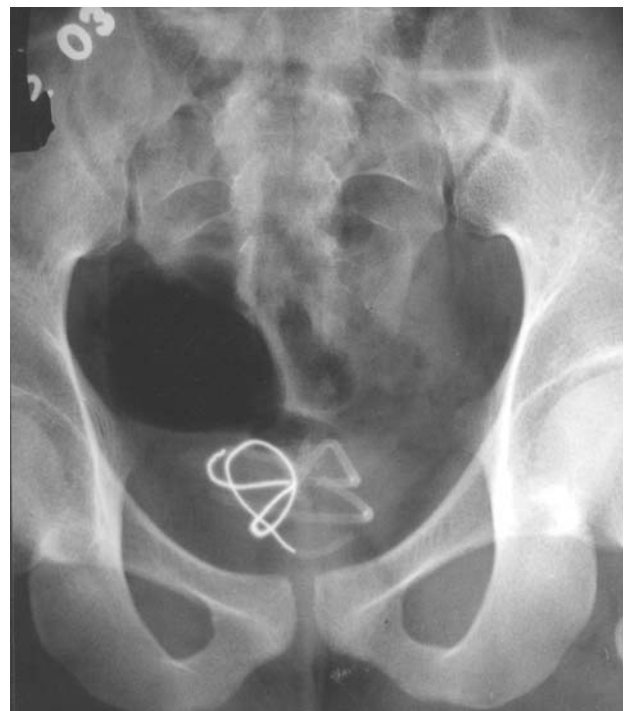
X-ray of the pelvis showing coiled up wire in urinary bladder.
